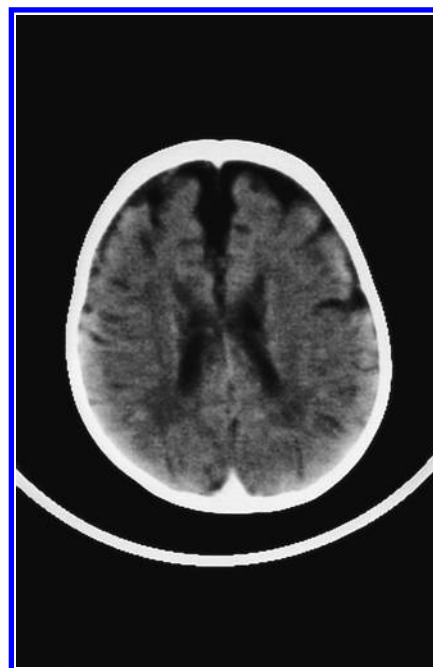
Computed tomography scan of the brain of the five-month-old patient shown in Figures 47.5 and 47.6. There was already marked atrophy of the brain, particularly evident over the frontal lobes. She died shortly after discharge.
